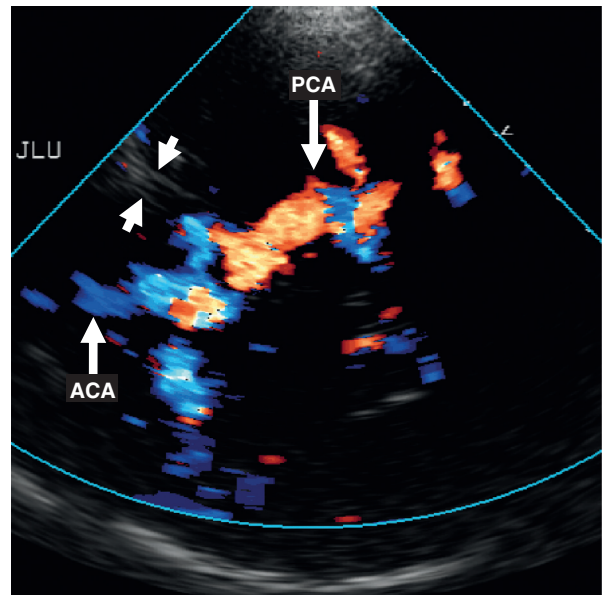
Proximal middle cerebral artery occlusion (arrows). No Doppler signal could be detected where the middle cerebral artery should appear. The remaining arteries can clearly be identified. ACA = anterior cerebral artery; PCA = posterior cerebral artery.
